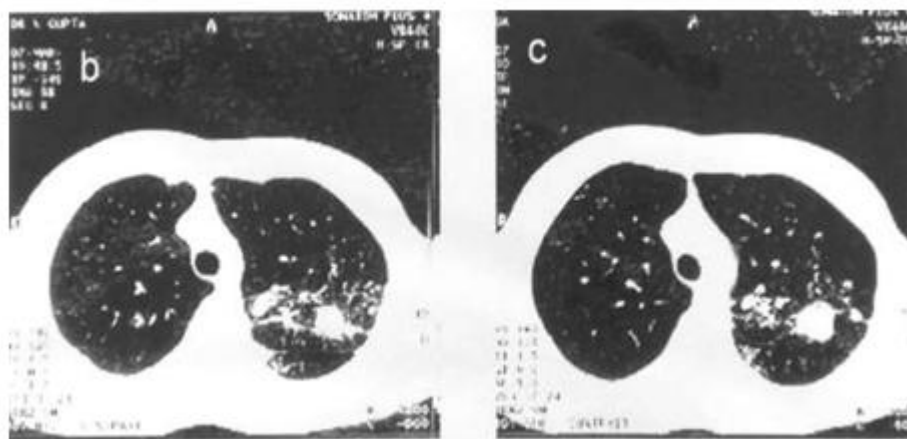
(b,c) HRCT scans of the lung reveal multiple centrilobular nodules in apicoposterior segment of left upper lobe with peribronchial thickening. A nodular area of consolidation is also seen in posterior segment in this sputum positive case of tuberculosis.
